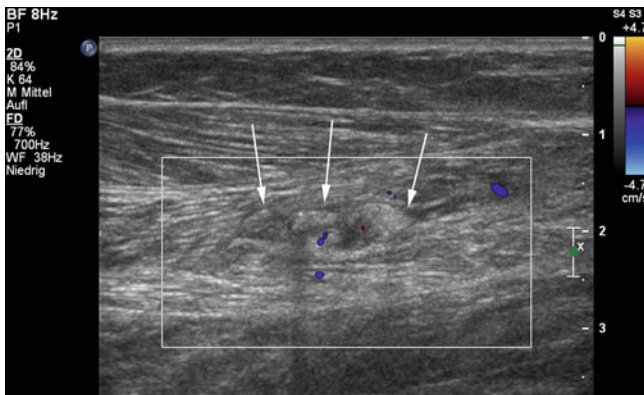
Color Doppler ultrasound image after sclerotherapy of venous malformation: a marked reduction of lesion volume, fibrous remodeling (*arrows*) and no detectable flow is demonstrated confirming good response
